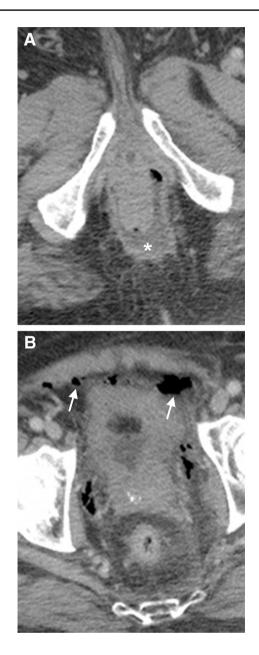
Fournier gangrene secondary to an ischioanal abscess. a, b Axial enhanced CT images show a horseshoe ischioanal abscess (*) with an extension of soft tissue gas to the extraperitoneal spaces (arrow)
